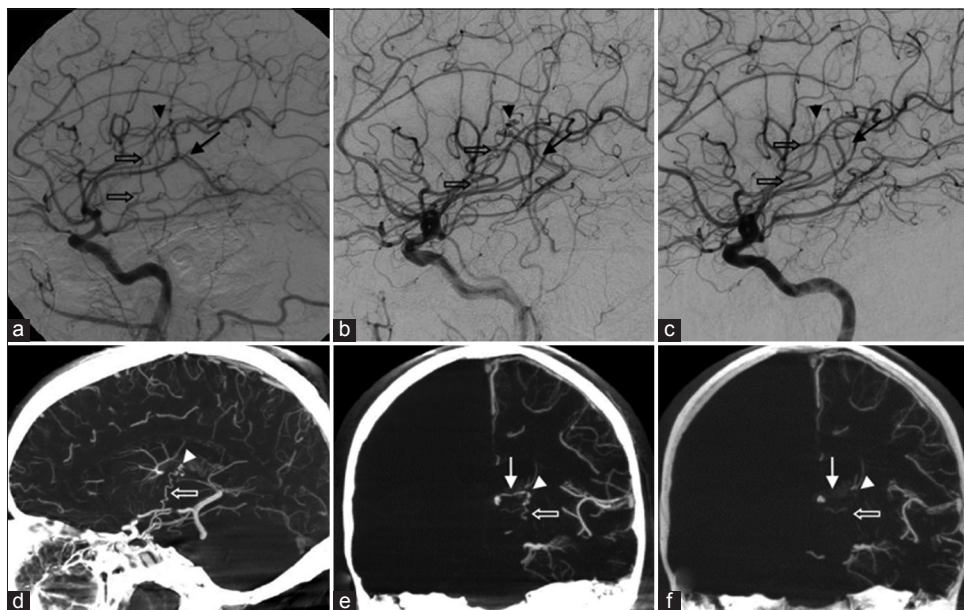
The arteriovenous malformation (AVM) nidus (arrowhead), seen on lateral digital subtraction angiography (a, b and c) and three-dimensional sagittal (d) and coronal (e and f) cone beam computed tomography reconstructions (left carotid injections), is fed by the left anterior choroidal artery (hollow arrow) and a thalamic perforator branch of the left posterior communicating artery (right vertebral injection, not shown), and drained by the left internal cerebral vein (solid arrow). (a) Hematoma obscures the nidus at presentation, (b, d and e) 3 months follow-up reveals the AVM, and (c and f) 7 months follow-up demonstrates complete spontaneous AVM obliteration
